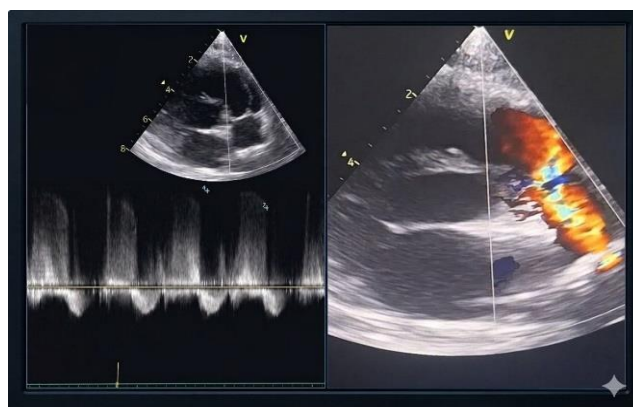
Echocardiogram with Doppler of PDA
